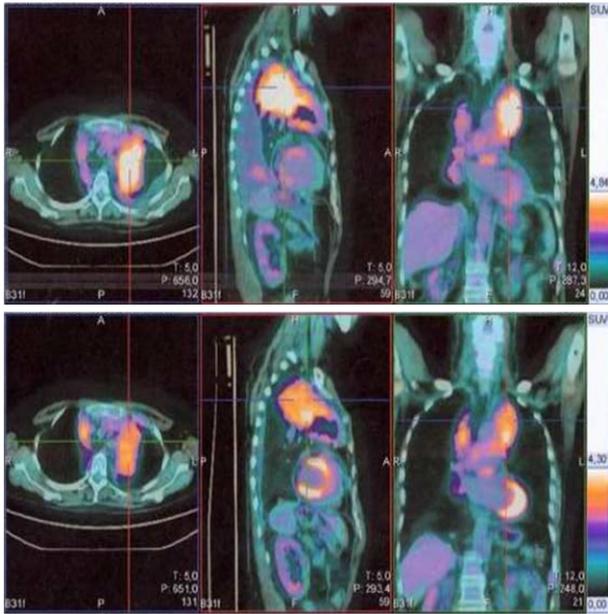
The marked decrease in fluoro-2-deoxy-D-glucose uptake in positron emission tomography/computed tomography performed in October, 2010 (below) in comparison to positron emission tomography/computed tomography performed in August, 2010 (above) in patient 1. Color scales are approximately the same.
